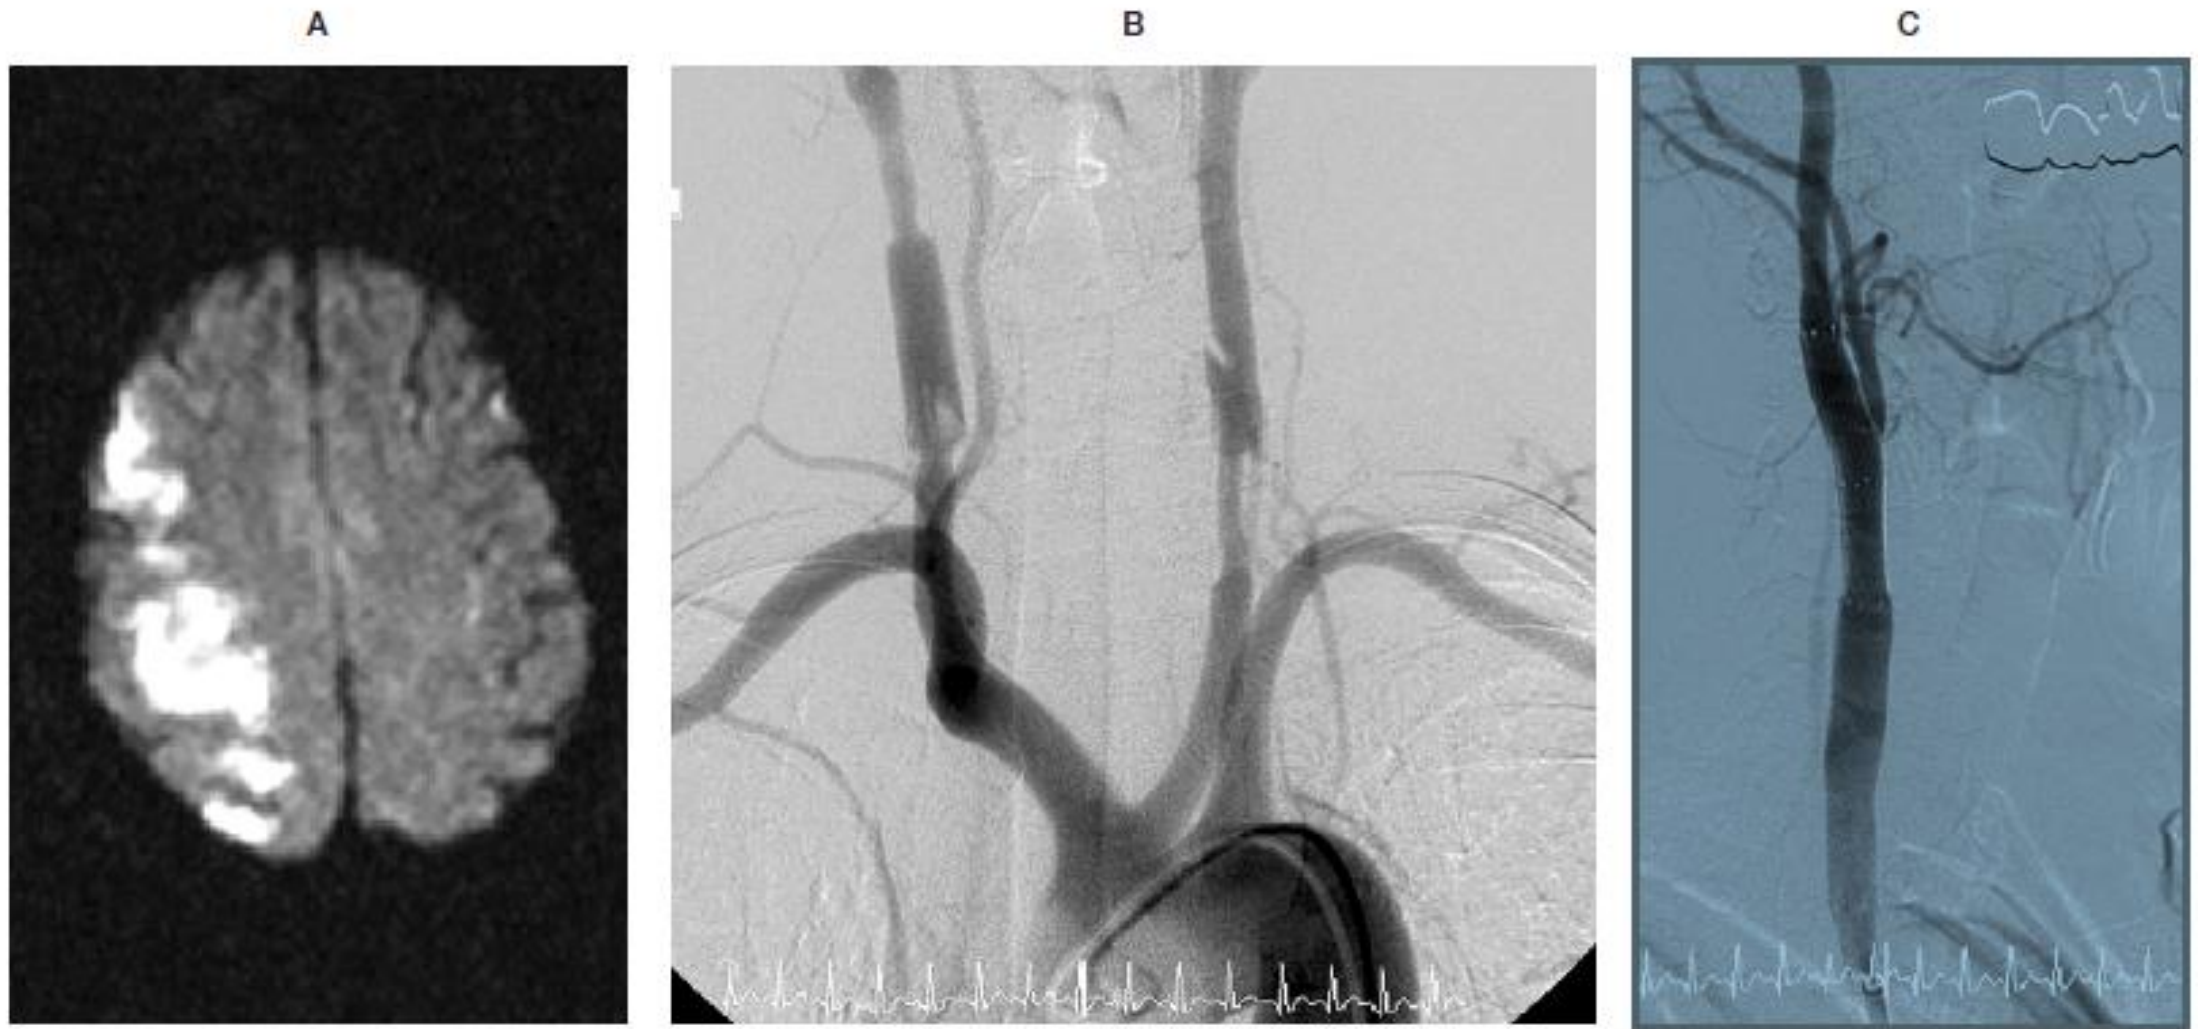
A) Diffusion-weighted magnetic resonance imaging (DWI) one day after the onset, showing new ischemic lesions in the right hemisphere. B) Aortogram one day after the trauma, showing bilateral common carotid dissection. Thrombus or intimal flap is recognized in the right common carotid artery (CCA). C) Right carotid angiograms after stent placement (right oblique view), revealing good patency of the right CCA.
